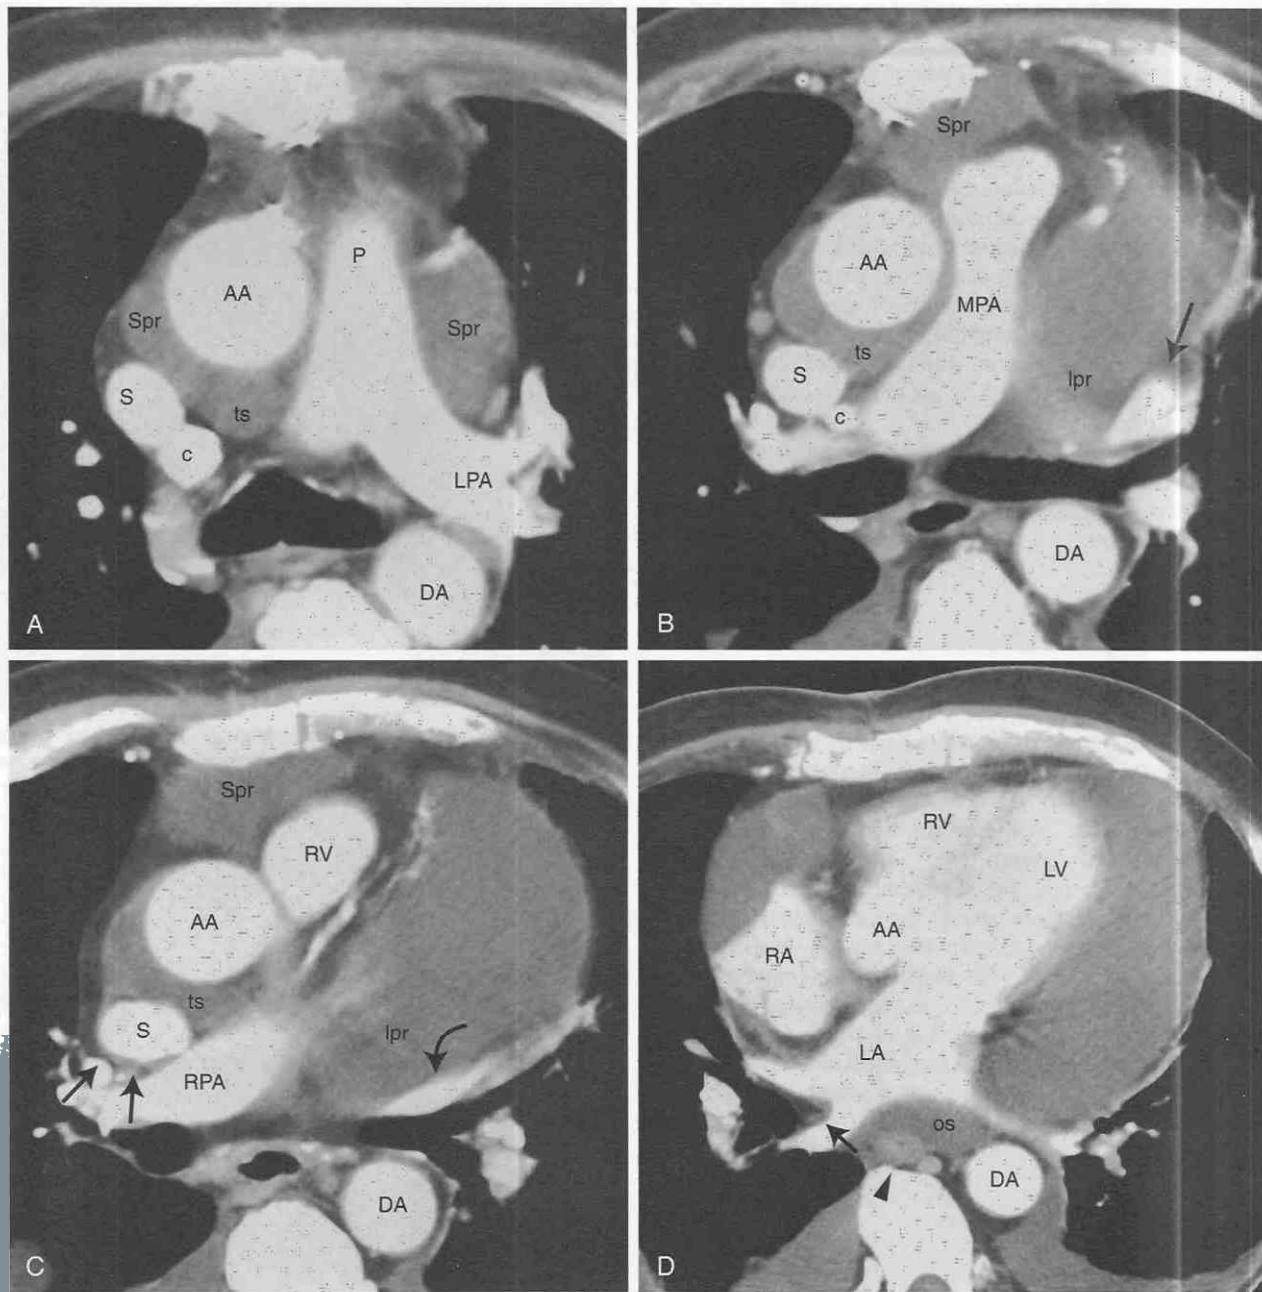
Pericardial effusion. Axial CT images following administration of intravenous contrast medium demonstrate the location of the pericardial recesses.
